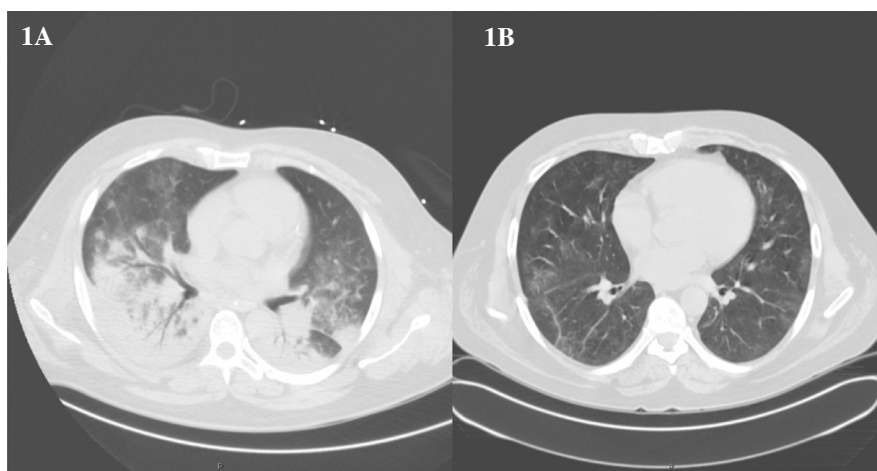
High-resolution computed tomography (HRCT) on the 7th day of hospitalisation. Extensive and bilateral pulmonary consolidation, with air bronchogram, and some parenchymal nodules. B. HRCT repeated after 42 days from the previous one, showing a resolution of the bilateral pulmonary consolidations with only some residual ground glass opacities left.
